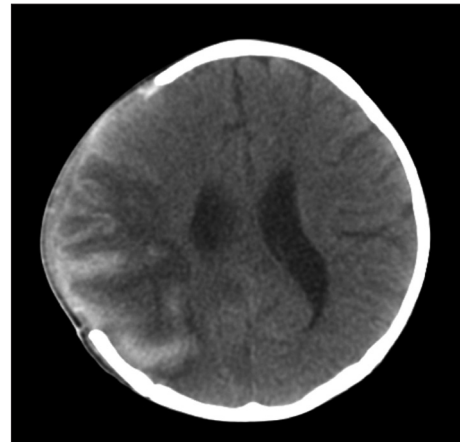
Brain CT at the time of post-operative 7 days revealed sustained brain swelling with decompressive craniectomy, but midline shift did not noted anymore.
